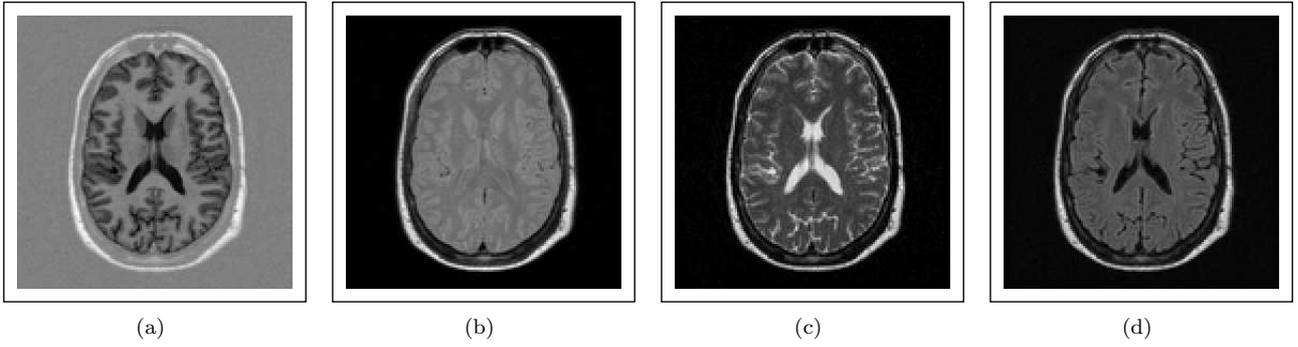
New data collected with Birdcage coil. (a) Inversion Recovery Turbo Spin Echo (IRTSE), (b) Variable Echo - Proton Density (VE-PD), (c) Variable Echo - T2 (VE-T2), and (d) Fluid-Attenuated Inversion Recovery (FLAIR)
